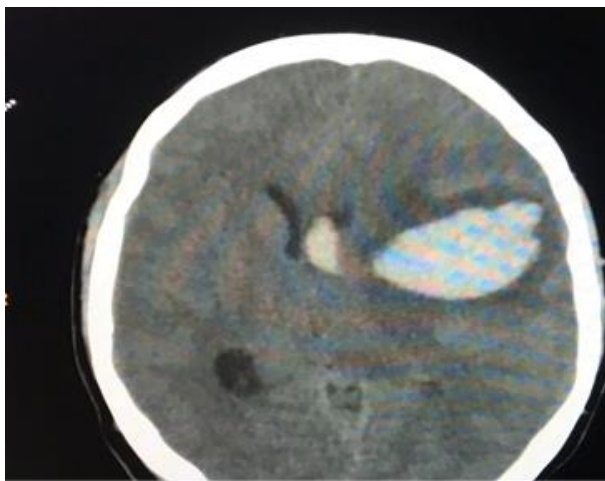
A non-contrast CT scan axial section showing a left lateral ventricular haemorrhage (IVH, left fronto-parietal
